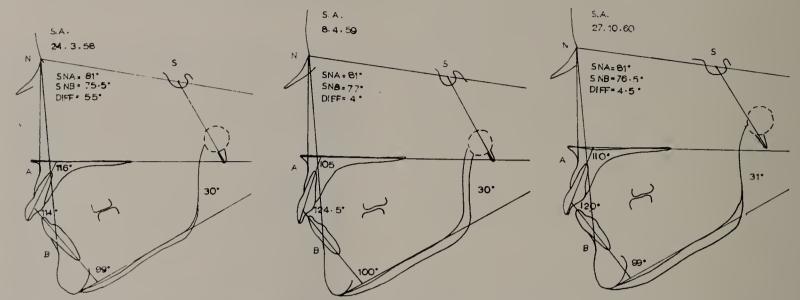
Tracings of lateral X-rays of case shown in Fig. 7. Tracings on right show occlusion eight months out of retention.
